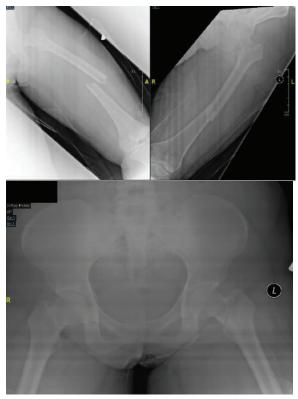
The initial plain radiographs of the patient on the day of trauma. Basal neck of femur fracture can be seen on femur and pelvis films.
